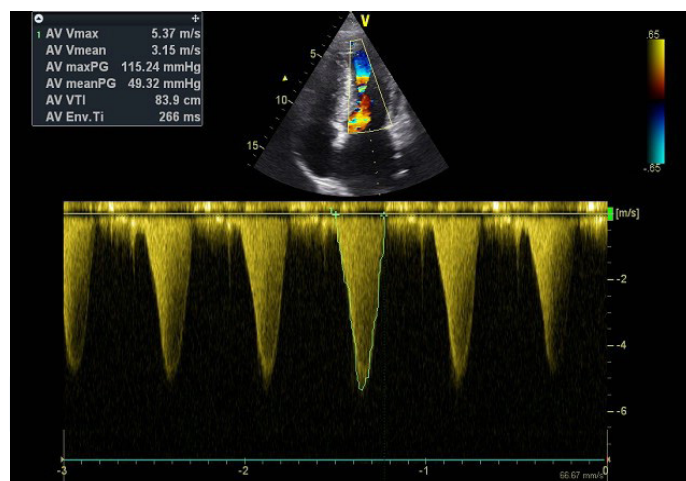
Apical four-chamber view, continuous width Doppler imaging presenting a high systolic velocity with the peak gradient of 115 mmHg.
